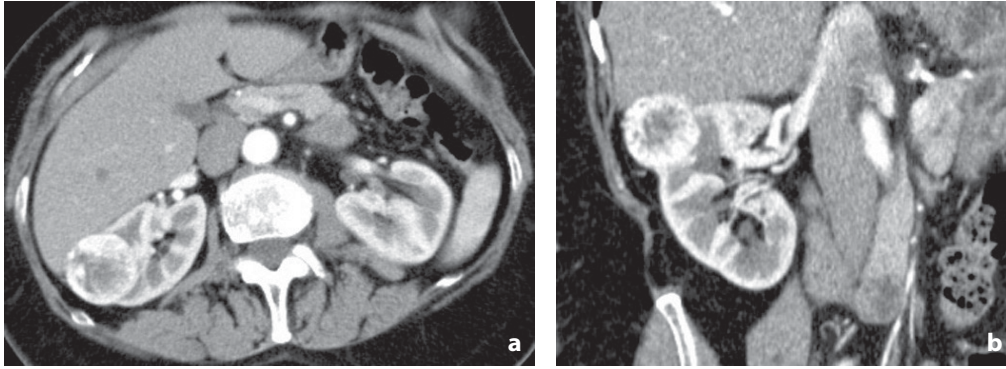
Computed tomography. Renal cell carcinoma. The stage T4 lesion shows no evident cleavage planes with the liver; probable invasion of the hepatic capsule
